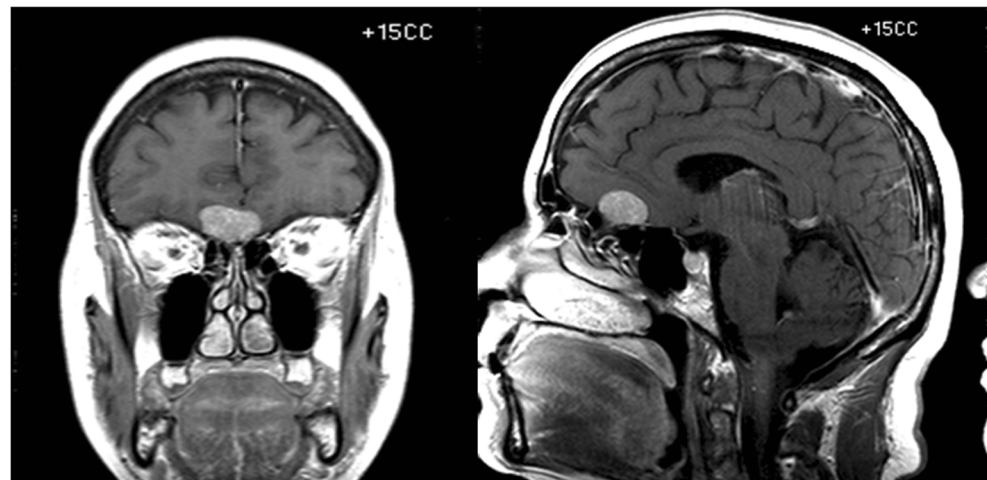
Preoperative MRI showing the 24 × 26 mm olfactory groove meningioma (OGM)
